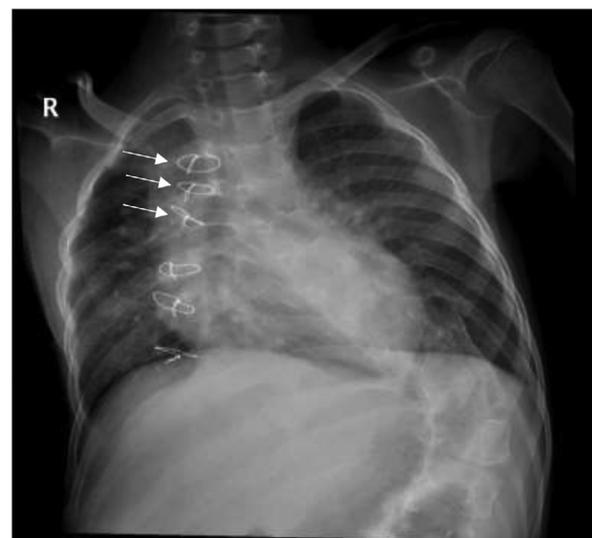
Frontal chest radiographs show thoracolumbar levoscoliosis and sternotomy wires (white straight arrows) at age of 8.
